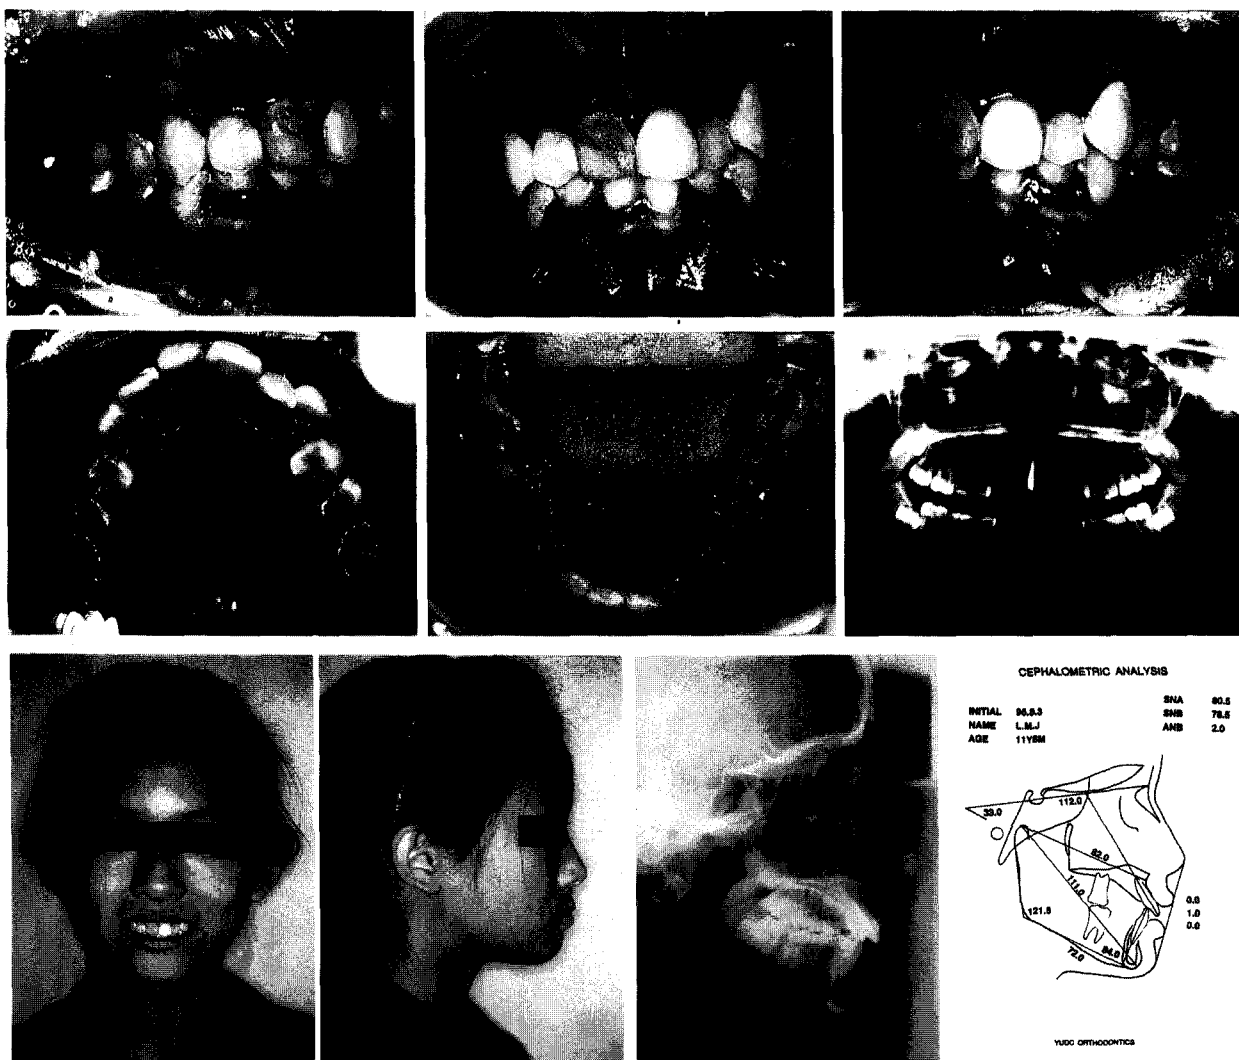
Pre-treatment Intraoral, extraoral photos and X-ray of case 1
